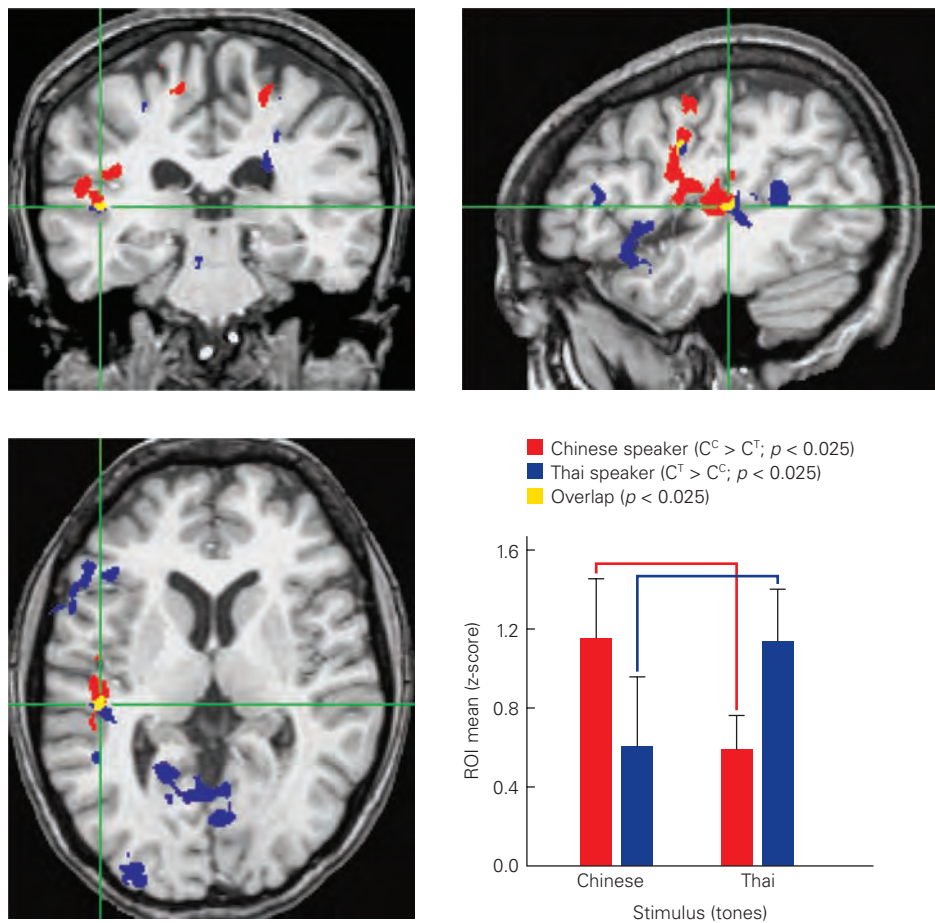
Brain activation for Chinese and Thai lexical tones revealed by functional magnetic resonance imaging. Language stimuli were composed of Chinese syllables superimposed with either Thai tones (C^T) or Chinese tones (C^C). Both native Chinese and native Thai speakers demonstrated a left hemisphere (LH) dominance when listening to their native tones. In the Chinese speakers, activation of the left hemisphere was stronger for Chinese tones, whereas in the Thai speakers, activation was stronger for Thai tones. Overlap for the two
